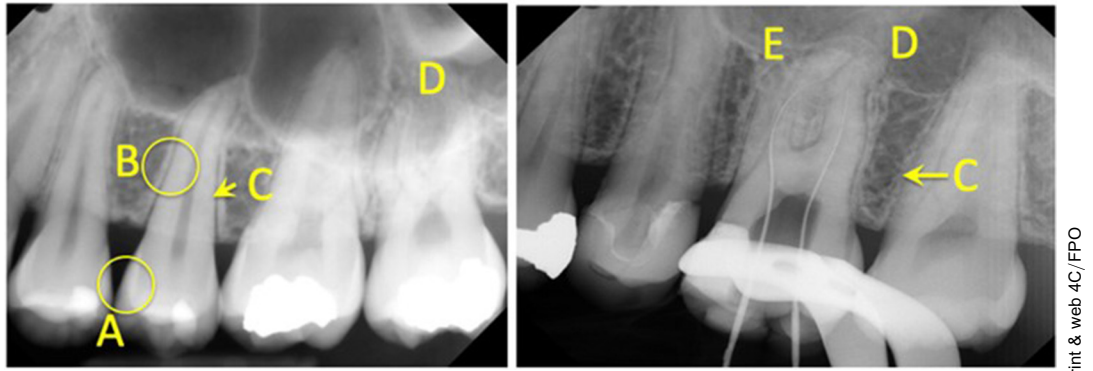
Multiple diagnostic applications associated with a single periapical radiograph. A. Caries diagnosis: contrast resolution. B. Identify lamina dura: contrast resolution. C. Identify periodontal ligament space ($\approx 200 \mu\text{m}$). D. Assess periapical bone: contrast resolution. E. Identify size of no. 6 0.02 K-file.
